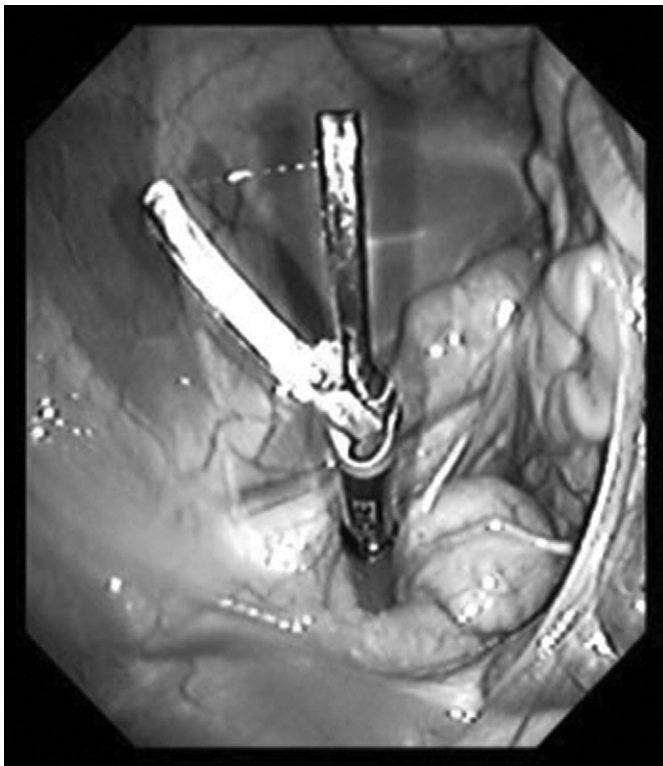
Gastroscopic view of entrance of ultrasonic scissors into abdomen by transvesical port.
